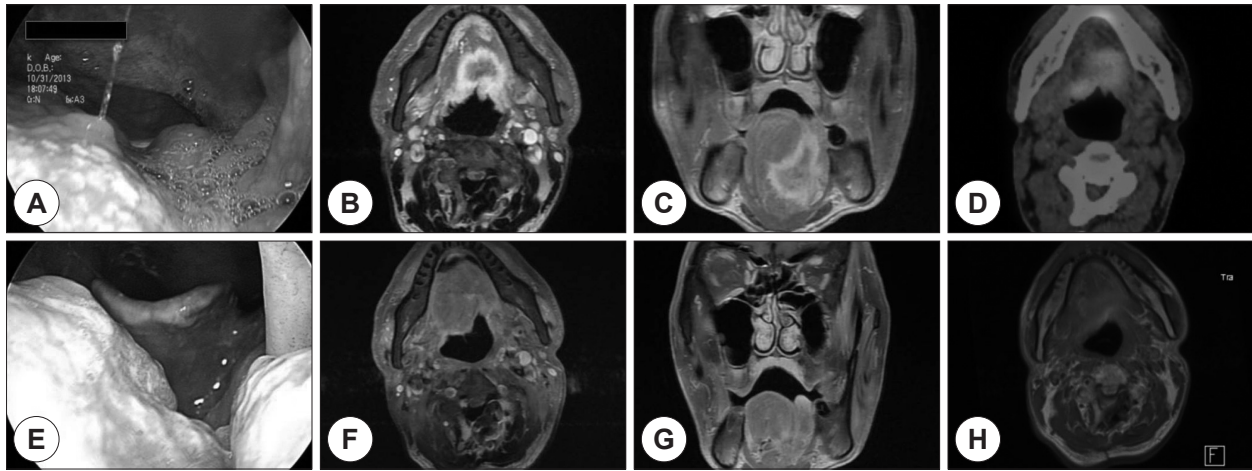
Laryngoscopic, MR, PET/CT and PET/MR images of patient B. Laryngoscopic image(A), T1 axial/coronal contrast-enhanced image(B and C) and PET/CT(D) image before treatment showed 3.7 cm-sized tongue base mass with hypermetabolism. Laryngoscopic image(E) at 9 months after treatment showed no abnormal lesion. T1 axial/coronal contrast-enhanced image(F and G) and PET/MR(H) image at 11 months after radiotherapy showed no abnormal or hypermetabolic lesion.
